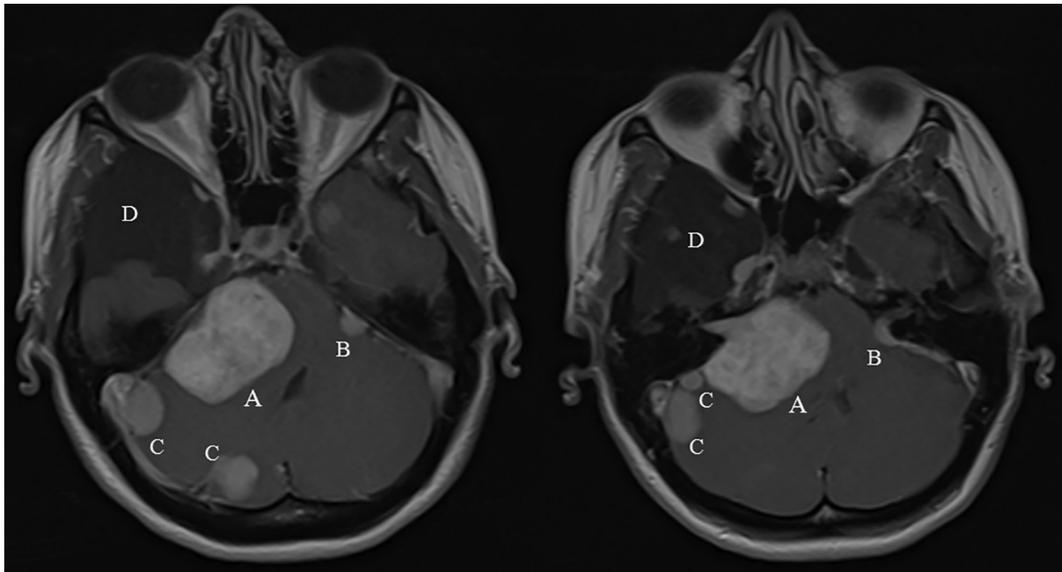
Preoperative MRI, T1 + Gd: Two-sided VSs in a patient with NF2. (A) Giant right-sided VS. (B) Small left-sided VS. (C) Right-sided caudal cranial fossa meningiomas. (D) Congenital arachnoid cyst of the right temporal lobe.
